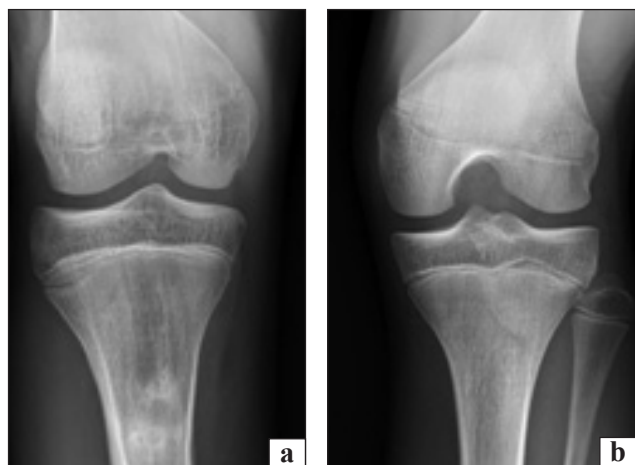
Photographs of X-rays of a 15-year-old patient N.: a) stable hip joint; b) unstable KJ in CMLL
